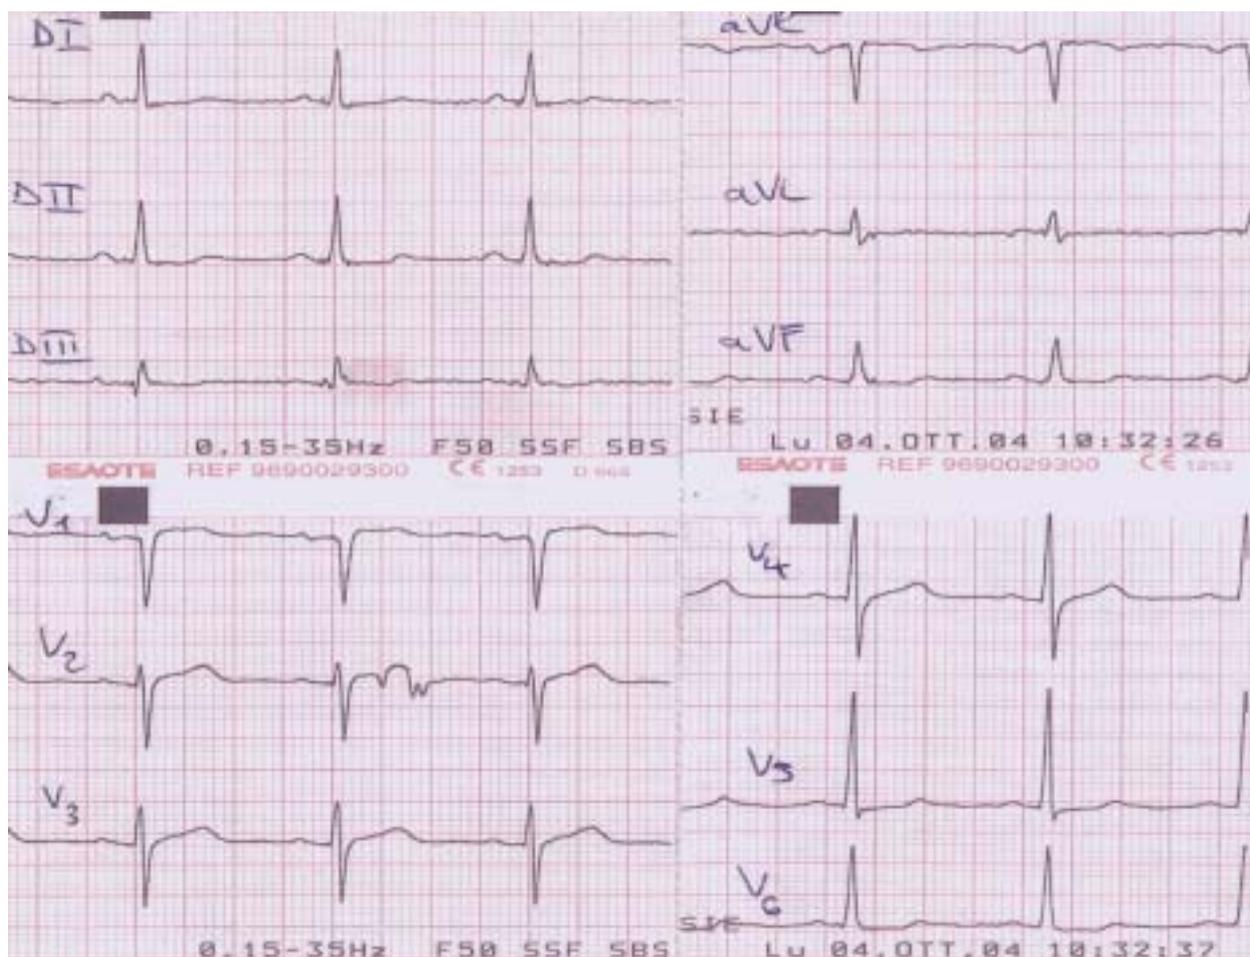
Echocardiogram, October 2004.
